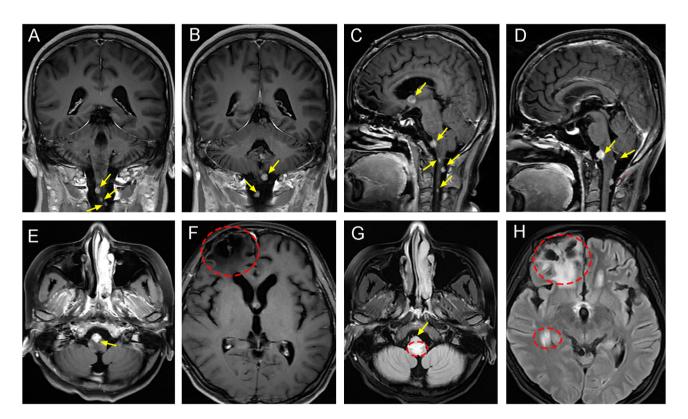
Tumor recurrence 8 months after lumbar spine surgery. (A) Coronal T1-weighted MRI showing recurrent lesion in the right frontal lobe. (B) Coronal T1-weighted MRI demonstrating surrounding edema. (C) Sagittal T1-weighted MRI displaying tumor recurrence along the surgical margin. (D) Sagittal T1-weighted MRI showing adjacent tissue compression. (E) Axial T1-weighted MRI revealing enhanced recurrent lesion. (F) Axial T1-weighted MRI indicating associated mass effect. (G) Axial diffusion-weighted imaging (DWI) showing restricted diffusion in the lesion. (H) Axial DWI confirming high signal intensity consistent with tumor recurrence. The yellow arrows indicate the tumor lesion and the red circles indicate the edema around the tumor.
